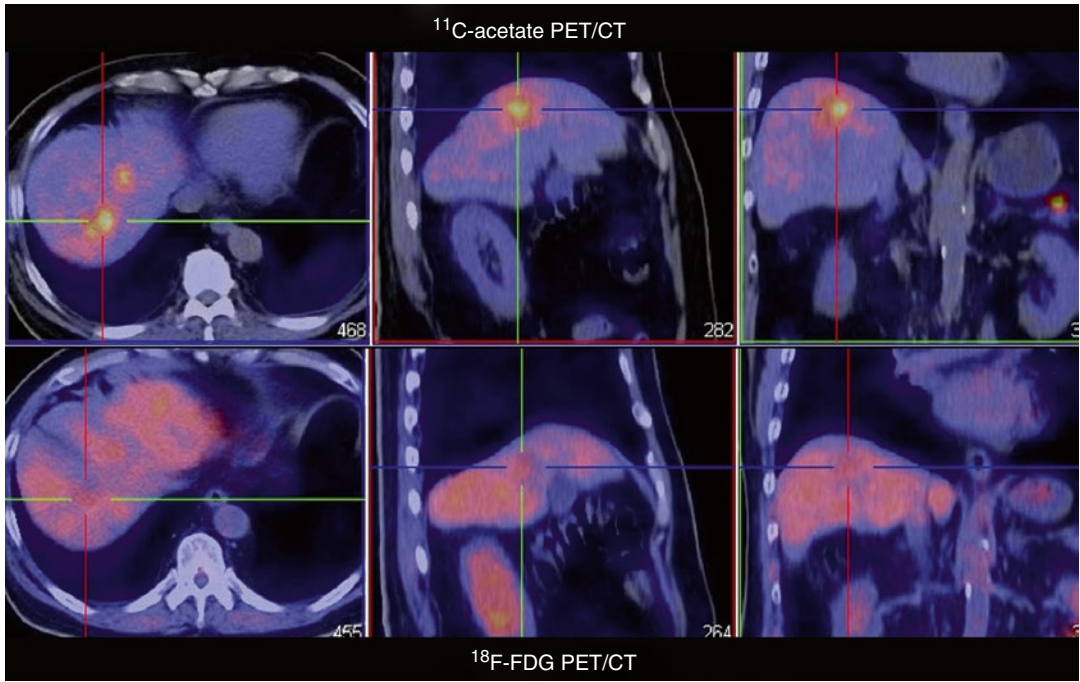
Multicentric well-differentiated HCC shows increased uptake of ^{11}C -acetate (*upper row*) but is negative on ^{18}F -FDG (*lower row*) PET/CT
